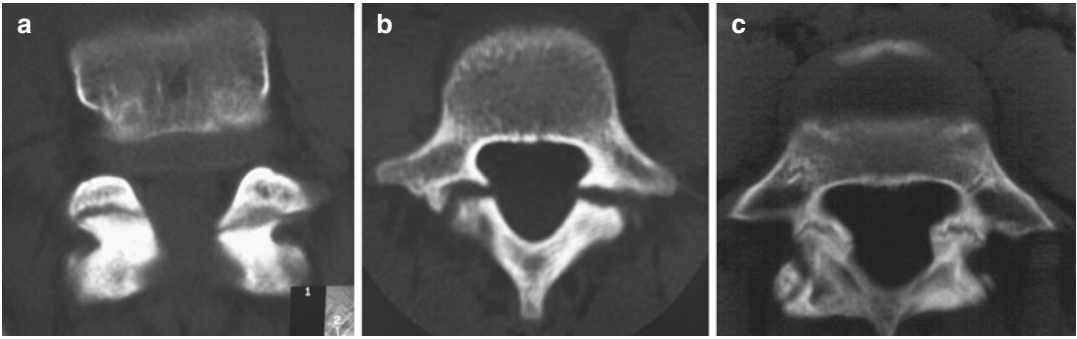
(a) Isthmus CT-image of a 10-year-old boy, “early-traumatic” spondylolysis. (b) Isthmus CT-image of an 11-year-old girl, “atrophic” spondylolysis. (c) Isthmus CT-image of an 14-year-old boy, “hypertrophic” spondylolysis
